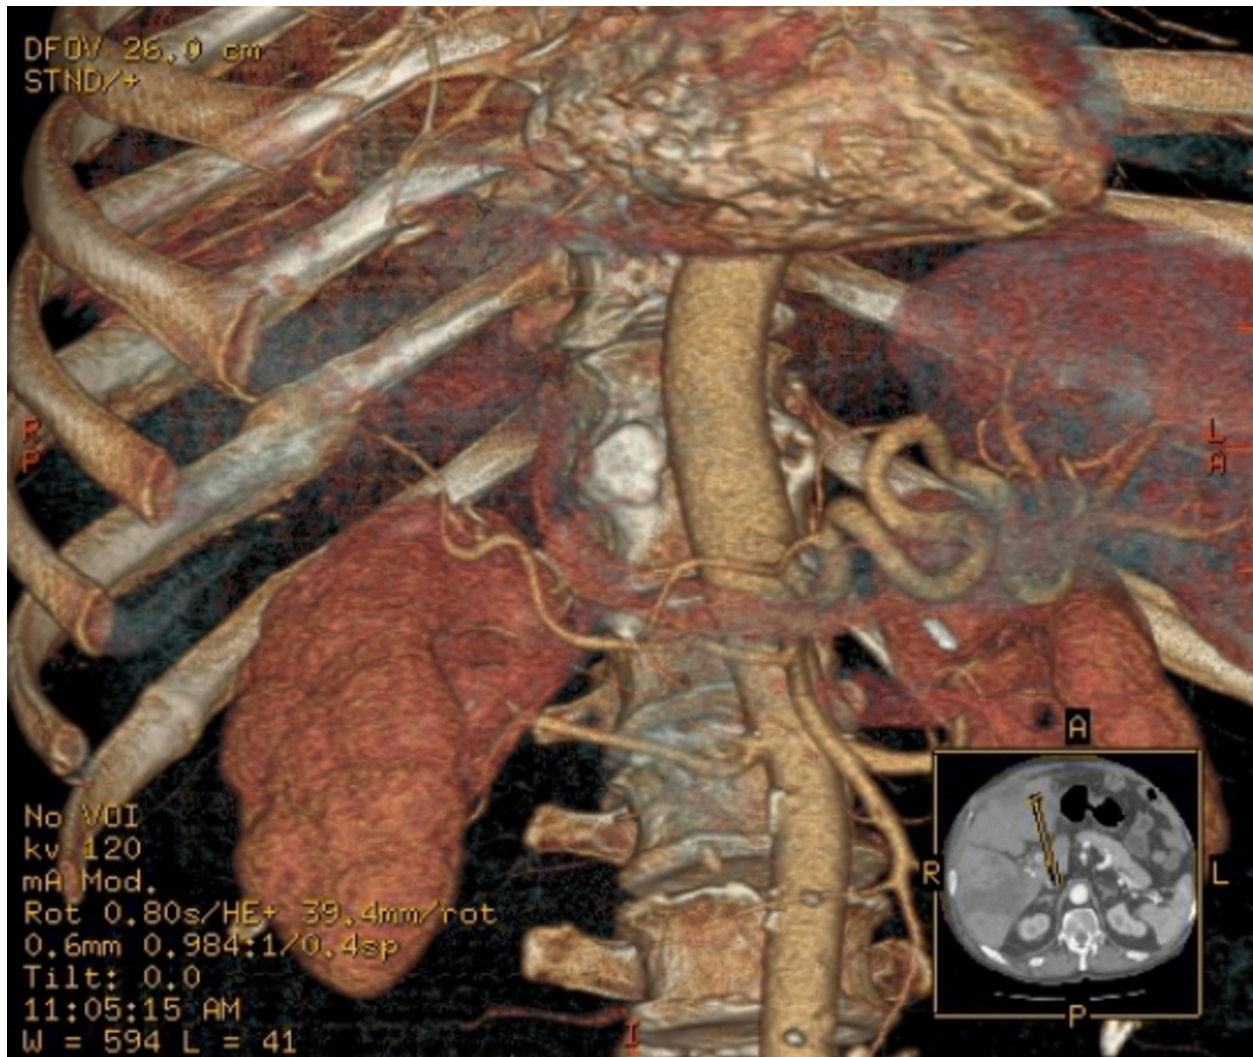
Three-dimensional volume-rendered CT angiography image showing a replaced right hepatic artery.
